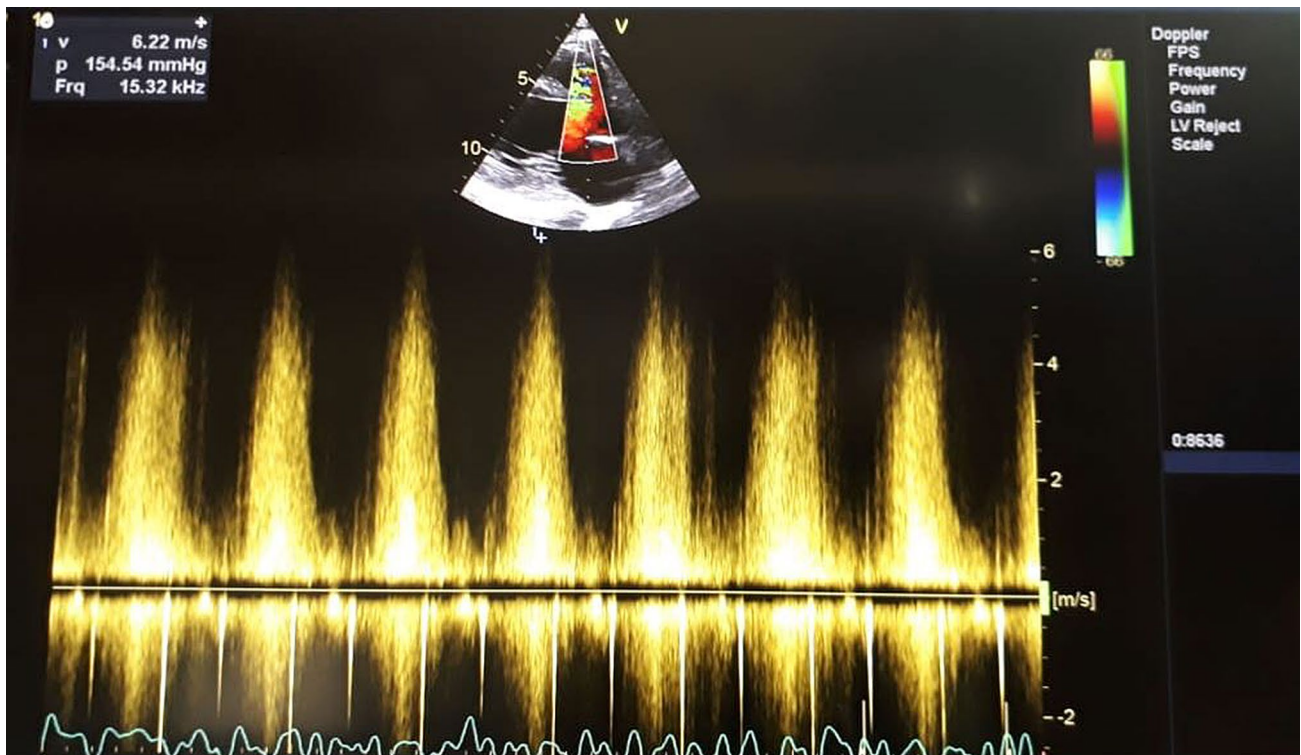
Doppler showing the peak pressure gradient of RSOVA
